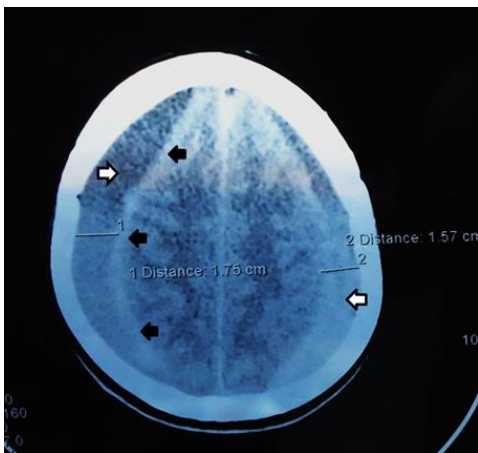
CT of bilateral chronic subdural hematomas(⇔)hemolised blood;(⇨) capsule
